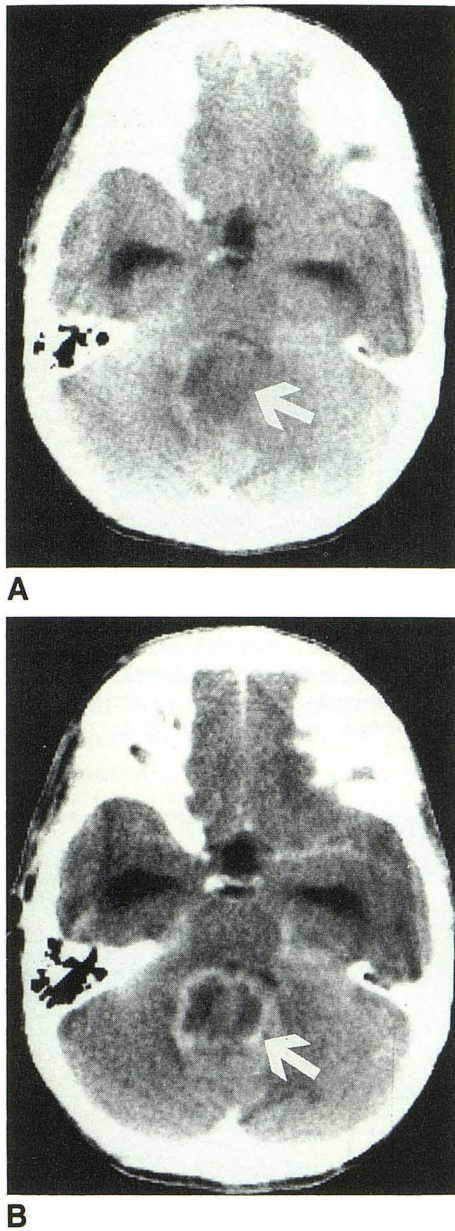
Fifteen-year-old boy with increased intracranial pressure. Pre- and postcontrast-enhanced CT (A and B) demonstrate a poorly defined midline posterior fossa tumor (white arrows) with mixed-density characteristics and irregular enhancement, along with hydrocephalus.
